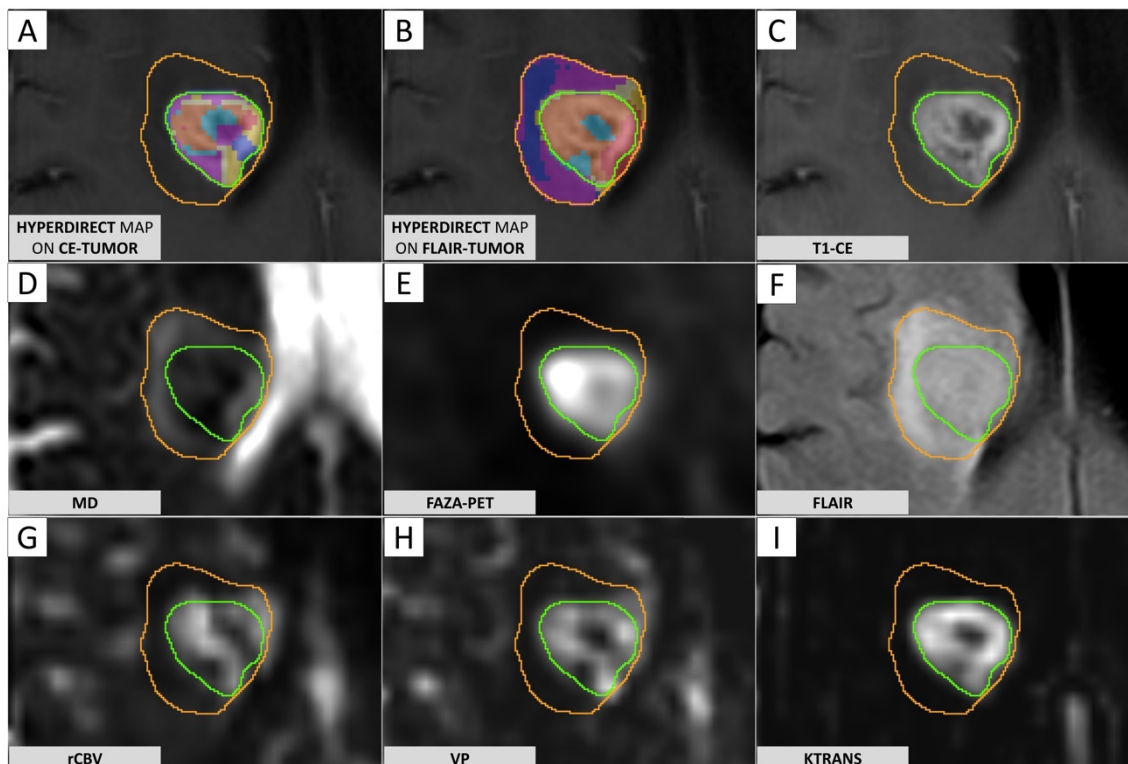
FLAIR-tumor and CE-tumor segmentations on different MRI sequences.
